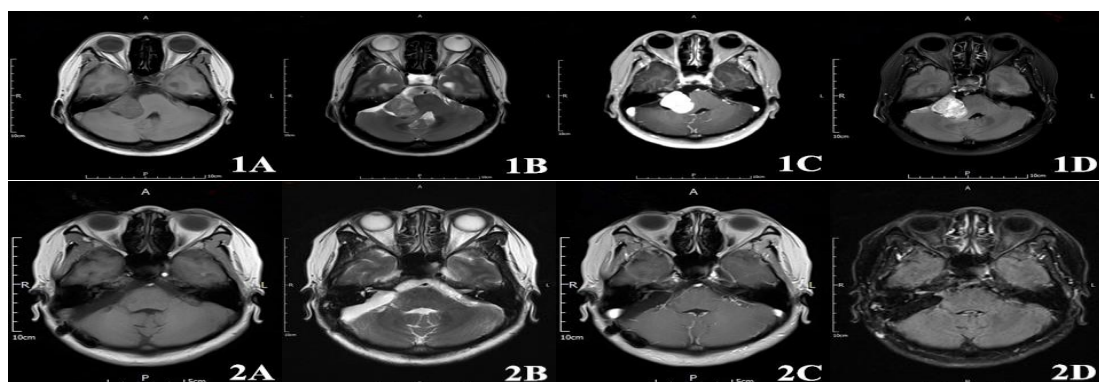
Representative pre-operative and post-operative MRI scans of one female patient (49 years old). The patient was hospitalized with a history of right hearing loss & headache, achieved a complete tumor surgical resection. Pathology result confirmed a Right Cerebellopontine Angle Acoustic Neuroma. 1A-1D showed pre-operative MRI T1WI, T2WI, Contrast and T2 Flair images. 2A-2D showed corresponding post-operative images.
